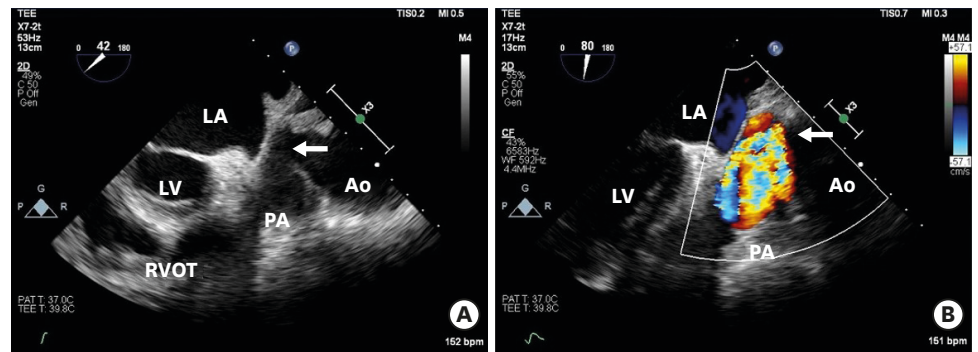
Transesophageal echocardiography in the ECMO insertion state. (A) White arrow indicates the tissue defect between the Ao and the main PA; (B) Doppler color-flow mode showing the flow communication between the Ao and the main PA. Ao = aortic arch aneurysm; ECMO = extracorporeal membrane oxygenation; LA = left atrium; LV = left ventricle; PA = pulmonary artery; RVOT = right ventricle outflow tract.
